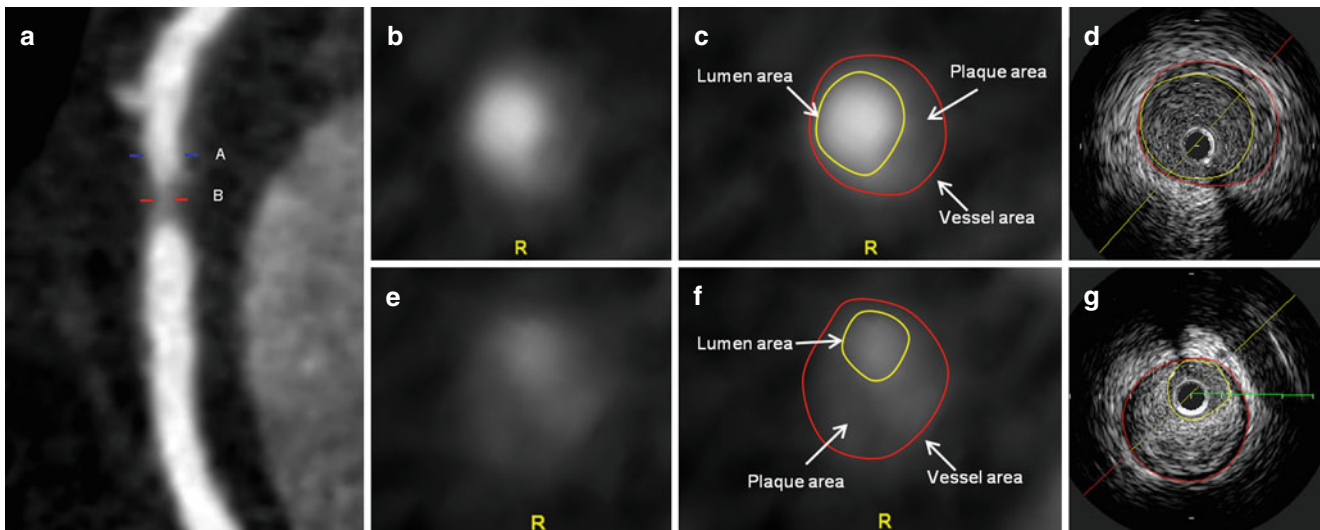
Comparison of plaque area using coronary computed tomography (CCTA) and intravascular ultrasound (IVUS) with significant coronary artery stenosis of the right coronary artery (RCA). (a) Curved multiplanar reformatted (MPR) image of CCTA demonstrates significant coronary artery stenosis in the proximal segment of RCA by non-calcified plaque. (b, c) Cross-sectional images of CCTA on the level of the Blue line (A) on image a. Measurements of vessel area, lumen area, and plaque area were 15.9, 5.5, and 10.4 mm², respectively. (d) Corresponding intravascular ultrasound cross-sectional image of non-calcified plaque. Measurements of EEM CSA, lumen CSA, and plaque area were 16.7, 5.6, and 11.1 mm², respectively. Red circle indicating
